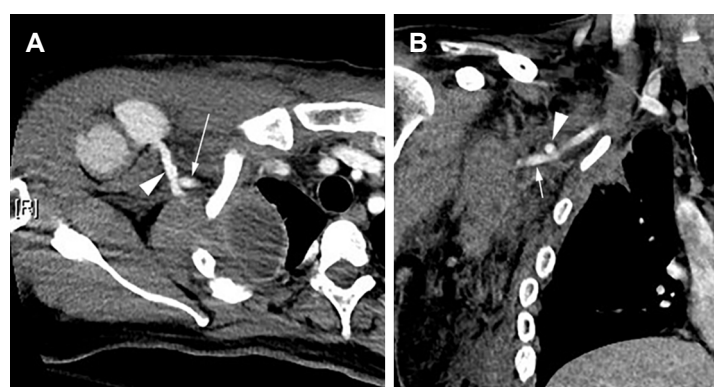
(A) Contrast-enhanced chest CT axial view reveals the penetrated axillary artery (arrow) and a track (arrowhead) tracing to the pseudoaneurysm. (B) Coronal view of the same lesion
